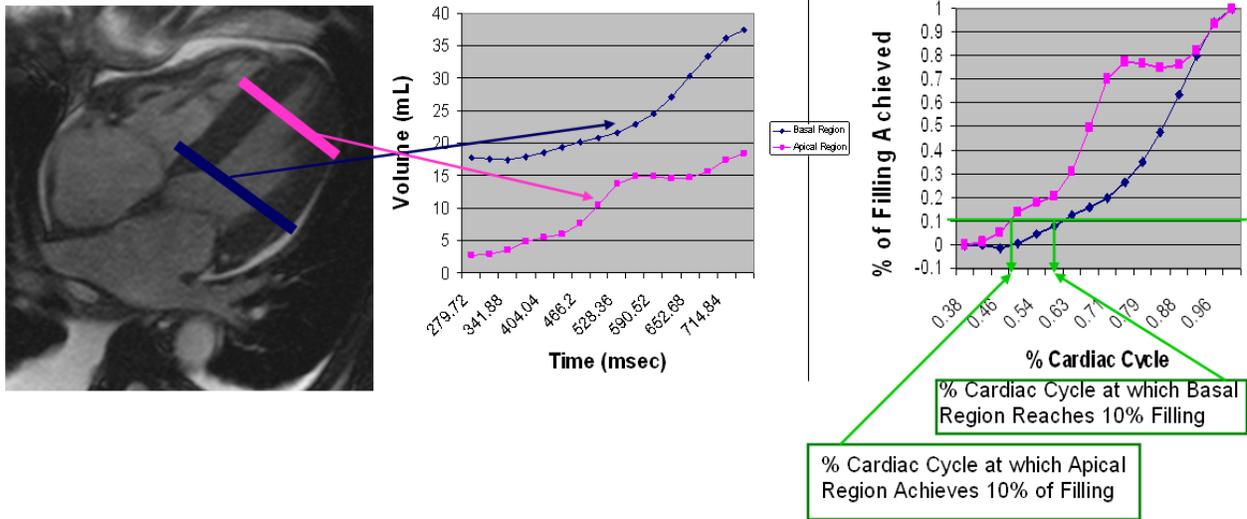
Cardiac MRI image demonstrating the typical position of the apical and basal slices used for this analysis. An example of the raw data of volume vs. time for the apical and basal regions is shown in the center. This raw data was transformed to demonstrate the % filling achieved over the % cardiac cycle (right). The green arrows show the points in the cardiac cycle when the apical and basal regions achieve 10% of filling.
